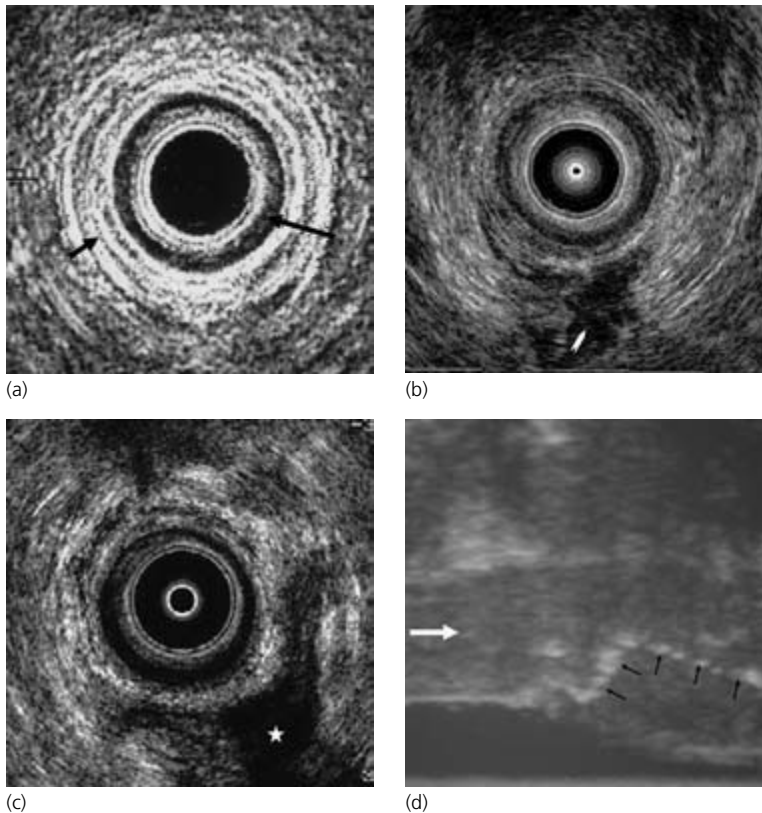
(a) Patient 1. Endoanal ultrasound demonstrating normal sphincter anatomy at the level of the mid anal canal (internal anal sphincter, long black arrow; external anal sphincter, short black arrow). (b) Patient 2. Endoanal ultrasound demonstrating posterior perianal fistula at the level of the mid anal canal (white arrowhead). (c) Patient 3. Endoanal ultrasound demonstrating posterior perianal collection at the level of the upper anal canal (white star). (d) Patient 4. Transrectal longitudinal ultrasound demonstrating thickened rectal wall (white arrow) with fistulous track (black arrows) extending above anal sphincter in rectal wall. The track is hyperreflective due to the presence of air within it. Fig. 4.1(a–c) courtesy of Dr. Mark Scott, Centre for Academic Surgery, Barts and The London, Queen Mary's School of Medicine and Dentistry, London, UK.
